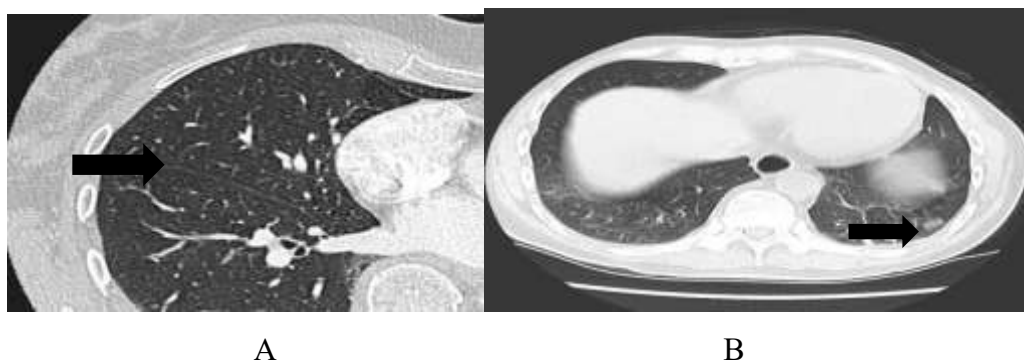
A) Axial contrast enhanced HRCT of the chest showing right lung perifissural nodule (arrow). B) Axial HRCT of the chest showing left lower lobar pleural based nodule (arrow).
